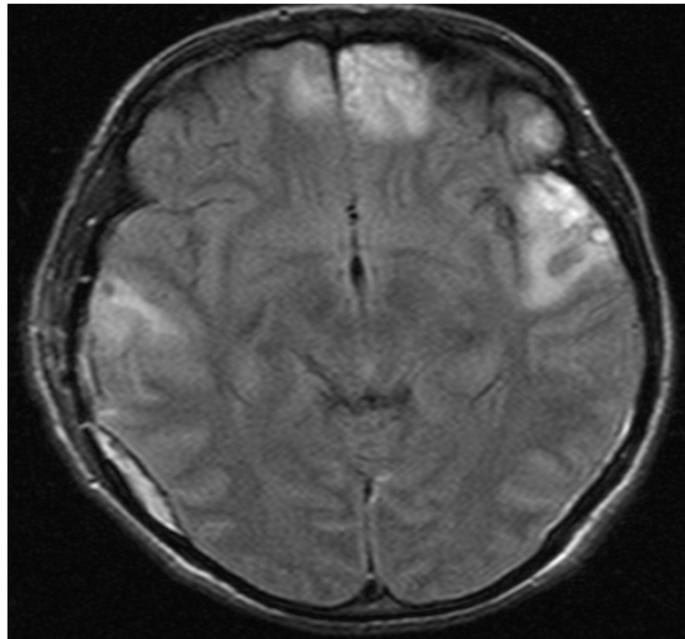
Cerebral MRI on hd15 showing subdural hematoma in the right parietal region and contusional lesions in the temporal and frontal regions bilaterally
